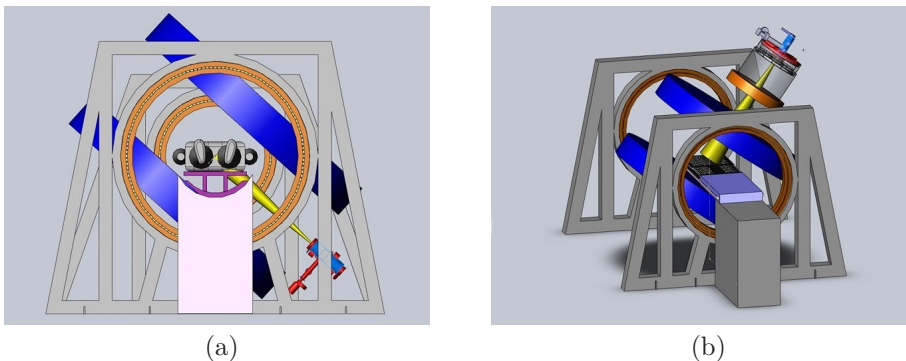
The Cross Cancer Institute MRI-linac design; (a) transverse configuration (radiation travels perpendicular to the magnetic field lines). (b) longitudinal configuration (radiation travels along the magnetic field lines). Courtesy of the Cross Cancer Institute.
